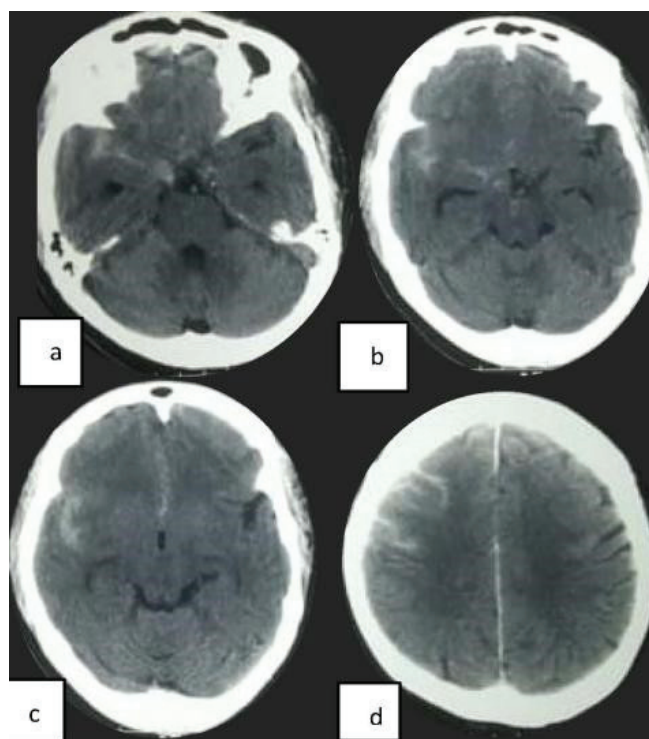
CT scan of brain done on the day of admission. a. acute subarachnoid hemorrhage involving the right sylvian fissure. b. extension of acute subarachnoid hemorrhage in the basal cistern. c. extension of acute subarachnoid hemorrhage in the anterior inter hemispheric fissure. d. acute subarachnoid hemorrhage involving the convexity of right frontal lobe.
